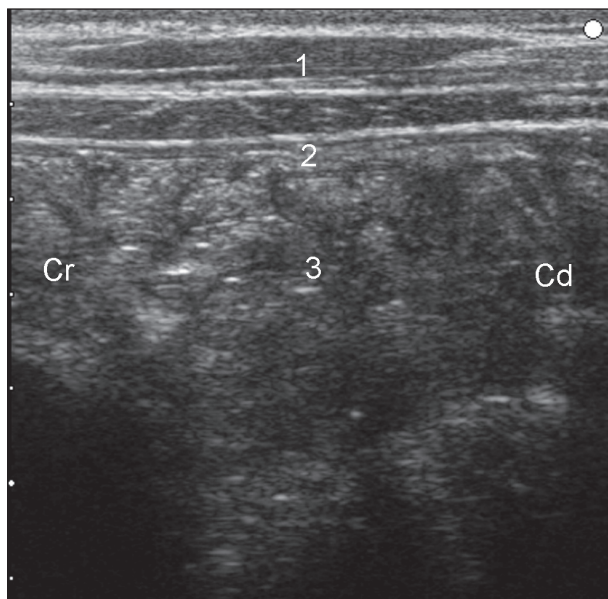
Ultrasonogram of the abomasum of a calf before feeding. A 5.0 MHz linear transducer was used to scan the ventral abdomen. The ingesta appear heterogeneous with echoic and hypoechoic components. 1 Ventral abdominal wall, 2 Abomasal wall, 3 Abomasal contents, Cr Cranial, Cd Caudal.
